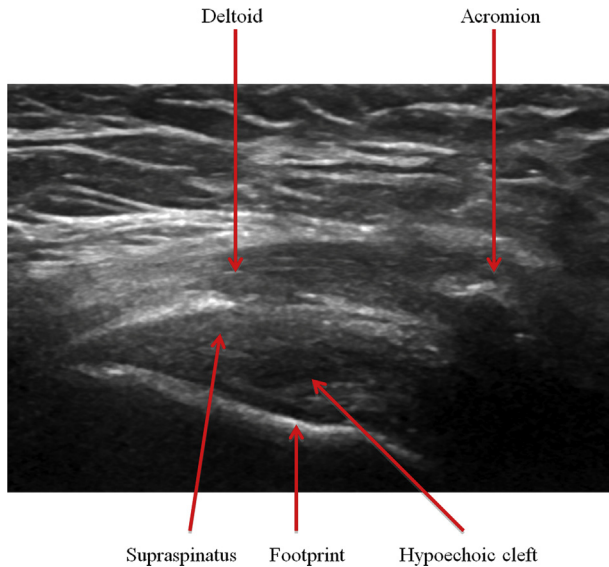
Long-axis ultrasonographic image of the supraspinatus tendon with hypoechoic cleft.
